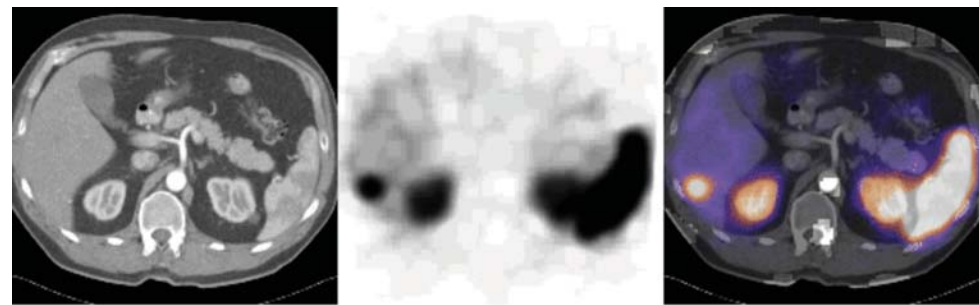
High resolution CT, poor resolution Indium-111 (¹¹¹In) octreotide SPECT and fusion SPECT/CT for neuroendocrine tumour detection and localisation.
